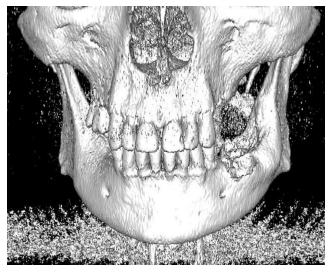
Three-dimensional (3D) computed tomography (CT) scan presenting the recurring tumor on the left side
